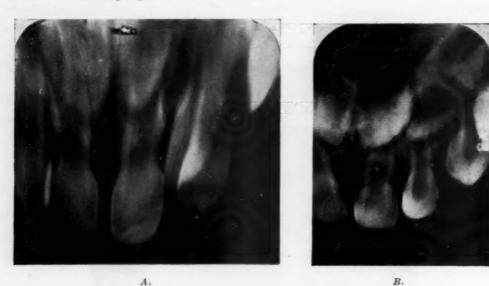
Radiographs of region of maxillary right lateral incisor tooth: A, Preoperative, visualizing supernumerary tooth superimposed on malposed deciduous lateral incisor. B, Seven months postoperative, showing lateral incisor erupted in normal position.
